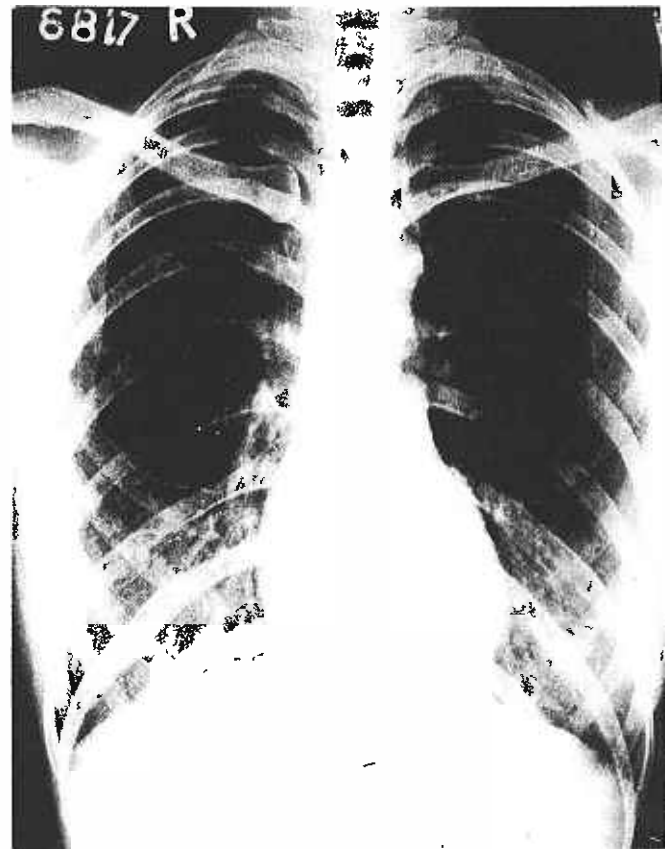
Chest radiograph taken in April 1978 shows an increase in lung volume, bilateral reticulonodular opacities and a large cyst in the right mid zone.
